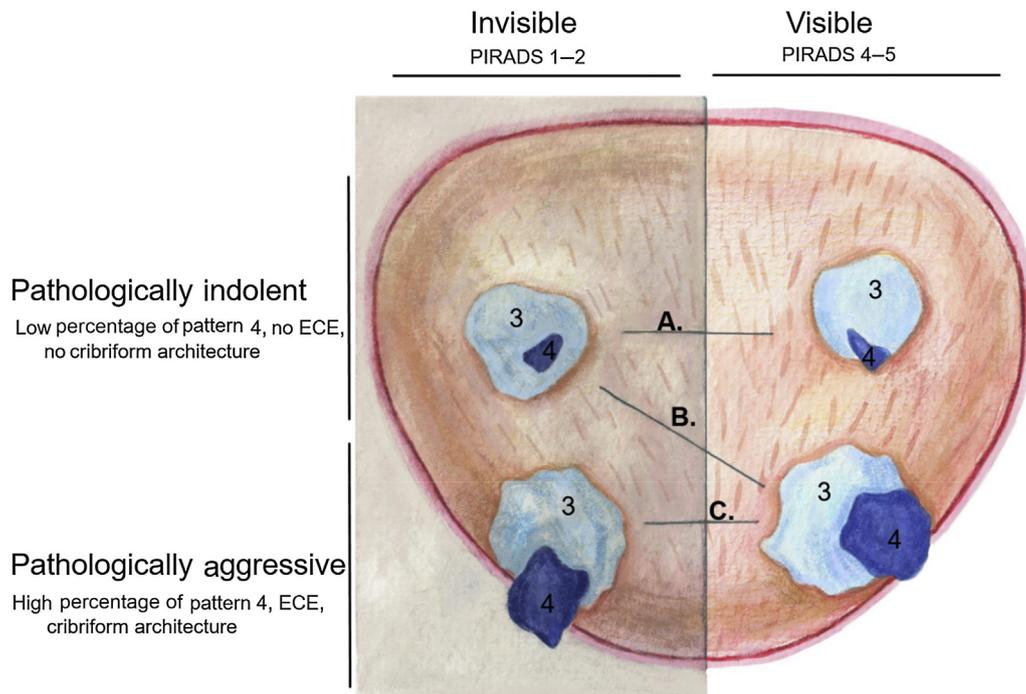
Potential comparisons of MRI-invisible and -visible tumors informed by genomic profiling. (A) Matched less pathologically aggressive tumors. Comparison can provide insight into the clinical significance of MRI-invisible lesions. (B) Less pathologically aggressive MRI-invisible tumor compared to more pathologically aggressive MRI-visible tumors as in the report by Houlahan et al. [1]. (C) Matched pathologically aggressive tumors. Comparison can inform the biology underlying MRI visibility or lack thereof. MRI = magnetic resonance imaging; ECE = extracapsular extension; PIRADS = Prostate Imaging Data and Reporting System.
